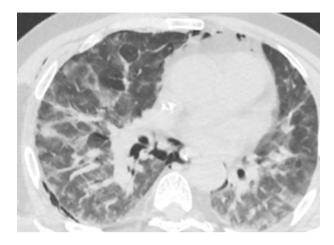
CT of patient after 4 days of conservative therapy
